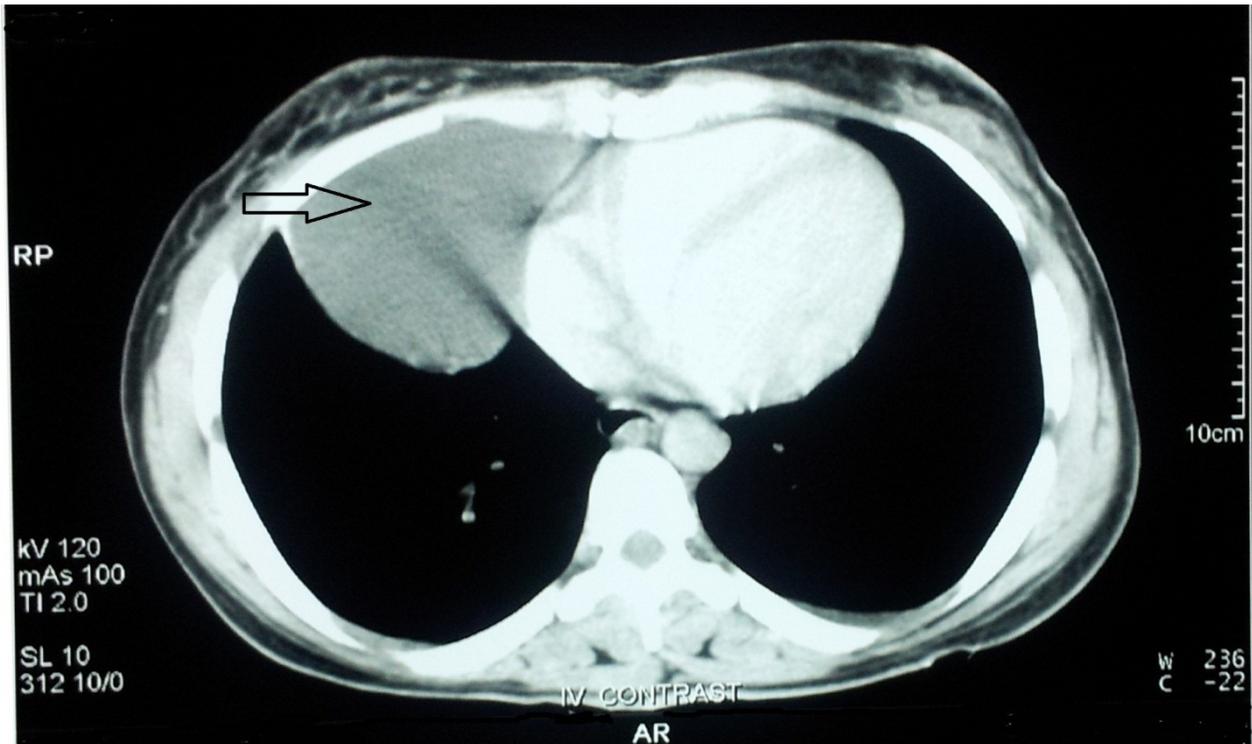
Axial CT of the chest showing anterior right cardiophrenic angle lesion. The attenuation of the content measured 19.1 Hounsfield unit (HU). Arrow pointing to the cyst
